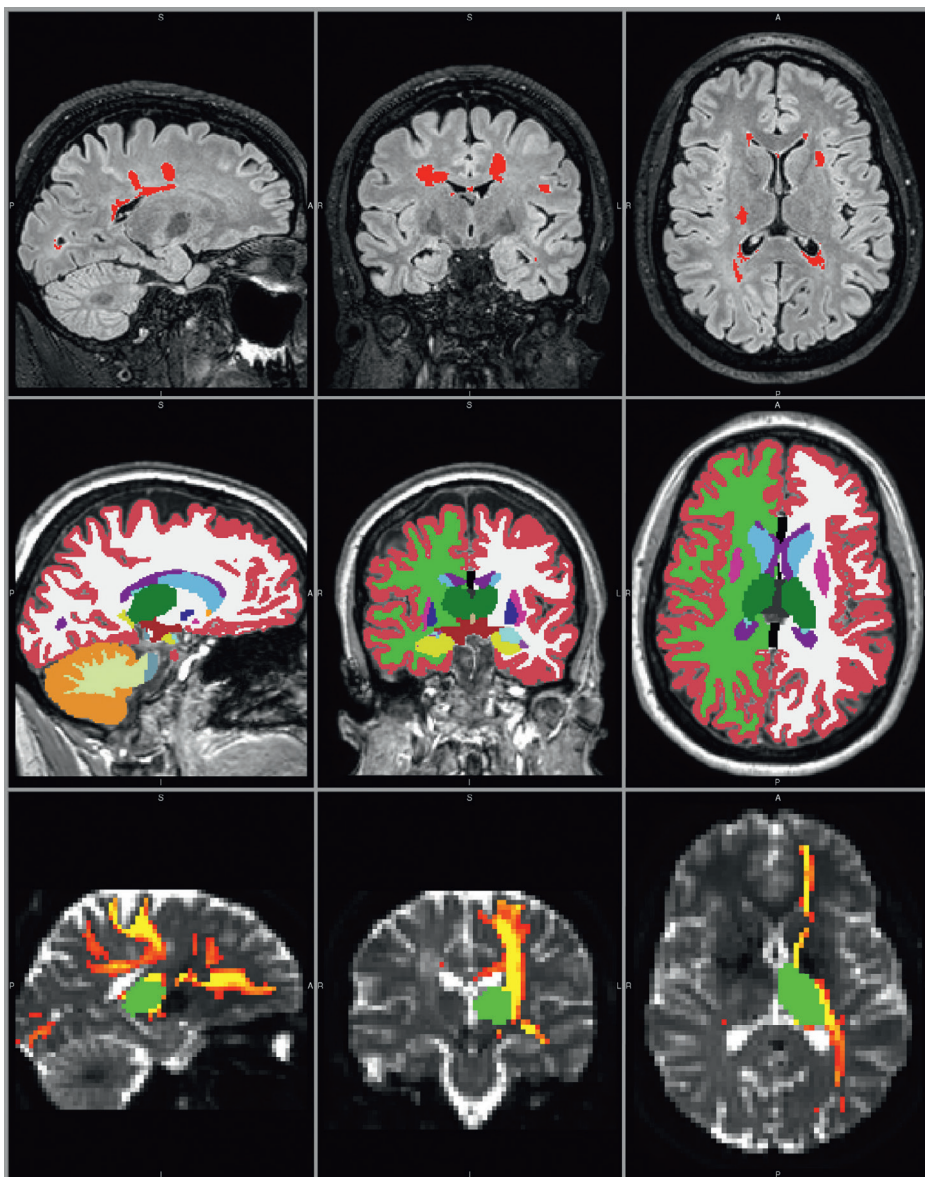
MRI processing example in a 28 year old female with RRMS.
